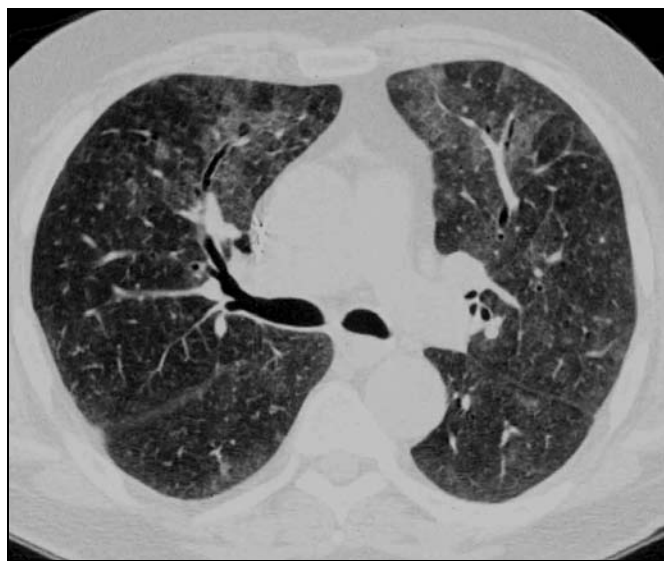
53-year-old man with pulmonary alveolar proteinosis. Slowly progressive high-resolution CT image through carina shows presence of ground-glass opacities with slight fine intralobular interstitial thickening. This combination of ground-glass opacities and interstitial thickening has been termed “crazy paving.”
